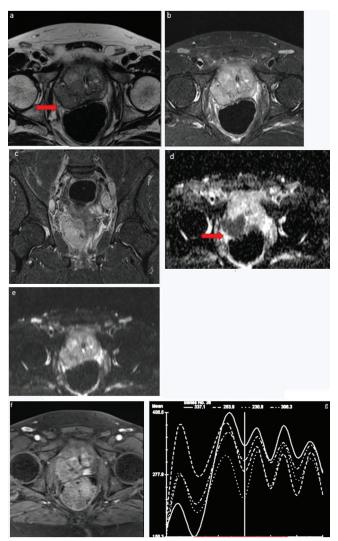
Axial T2 (a), Axial and coronal IR (b,c), DWI (d), ADC (e), Axial T1 post contrast (f) and DCE (g) images showing prostatomegaly with T2 hypointense lesions involving the transition and peripheral zones, showing diffusion restricton and dynamic contrast enhancement (Type III curve). Subtle extracapsular extension noted on right side. This is a PIRADS V lesion.
